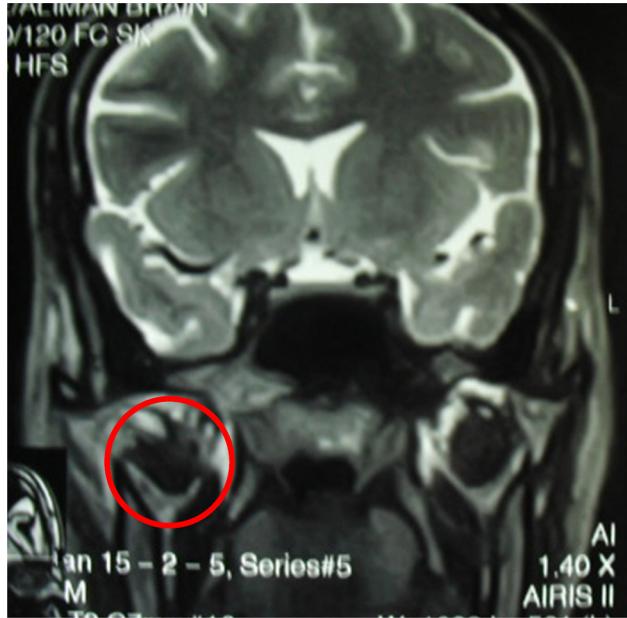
Coronal MRI showing involvement of the joint and of peri-articular soft tissues, and the presence of nodular tissue on the right condyle (circle).
